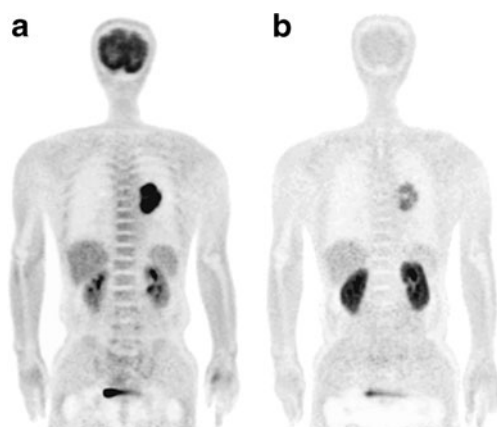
PET images of 62-year-old man with adenocarcinoma of left lung (p-T2N0M0). Both ¹⁸F-FDG (a) and ¹⁸F-FMT (b) showed increased uptake in primary tumor. Reproduced from [57]
